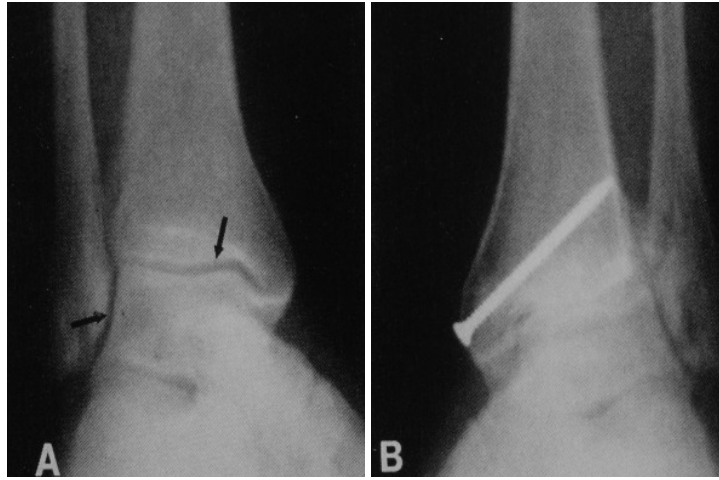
Conventional X-ray radiographs of (A) a normal and (B) an osteoarthritic ankle. In (B) an excess of mineralization and absence of a normal joint space are visible as hallmarks of OA (the screw is part of a joint fusion procedure). In (A), the joint gap visible between the two bones means presence of cartilage tissue; nothing can be said about the status of the cartilage itself.
